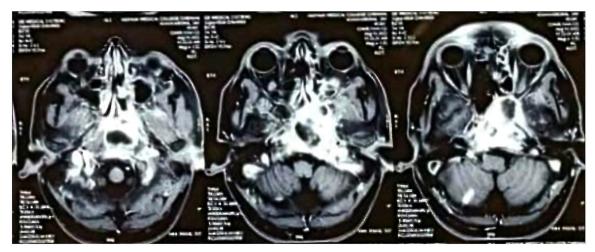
T1 weighted magnetic resonance imaging in the axial cut reveals a hyperintense mass that is solid-cystic in nature causing erosion of the sphenoid bone in the middle cranial fossa.
